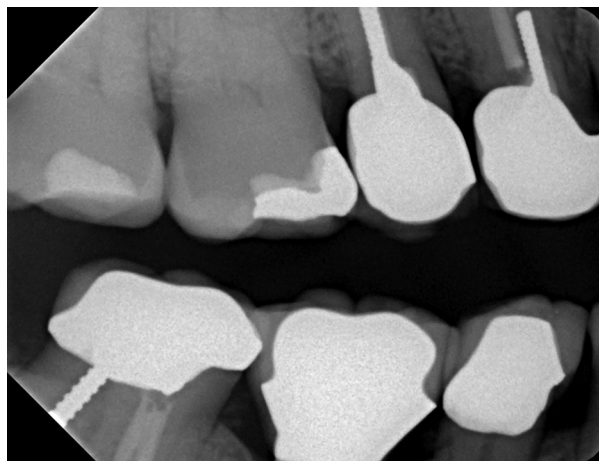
Radiograph showing delivery of an implant-supported restoration at site no. 30 on November 29, 2010. A broad, wide contact was confirmed clinically with floss.
